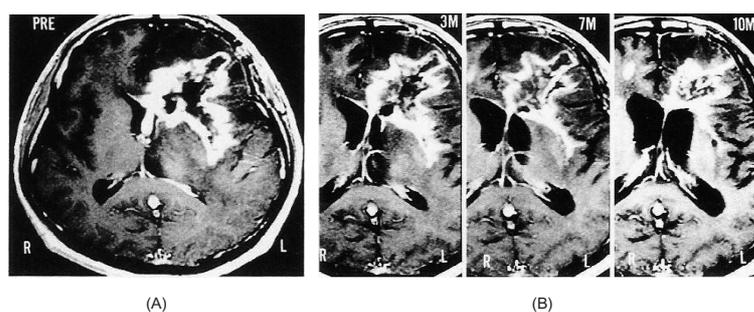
A, a glioblastoma multiforme of the left frontal lobe prior to therapy (33). Gd-enhanced MR imaging shows an irregularly enhanced tumor manifesting severe peritumoral edema of the left frontal lobe. B, Findings after the start of pritumumab therapy at 3 months (a), at 7 months (b), and at 10 months (c). These Gd-enhanced MR images show a decrease in tumor size, mass effect and peritumoral edema. These images also show the gradual enlargement of the lateral ventricles.
